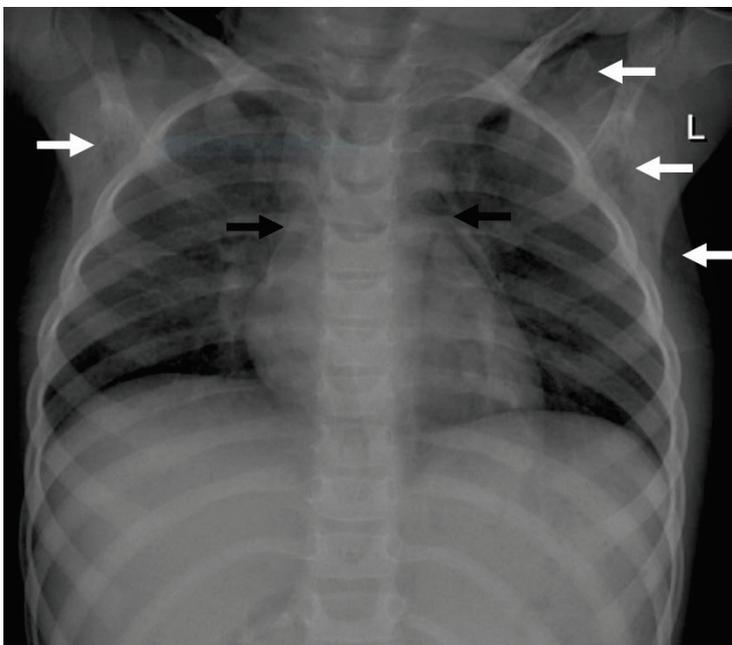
Imaging findings in patient 1. Chest X-ray showing a pneumomediastinum (black arrows) and a subcutaneous emphysema, more pronounced on the left site (white arrows).
